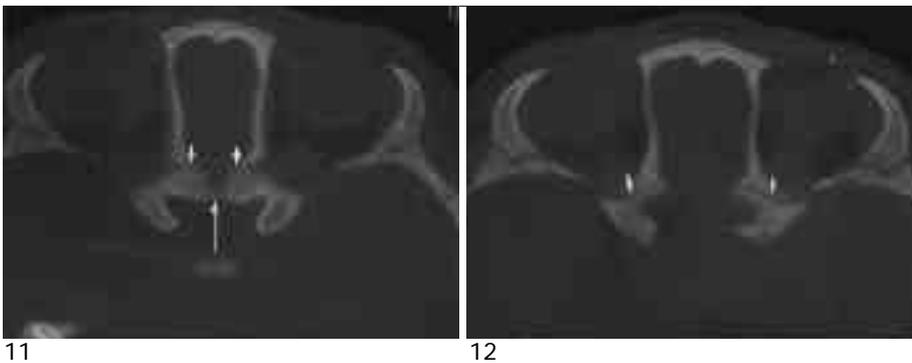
Axial CT scan shows grade 2 fusion of the sphenoethmoidal suture (short arrows) and interplanum sphenoidale (long arrow) in a 5-month-old female infant.
